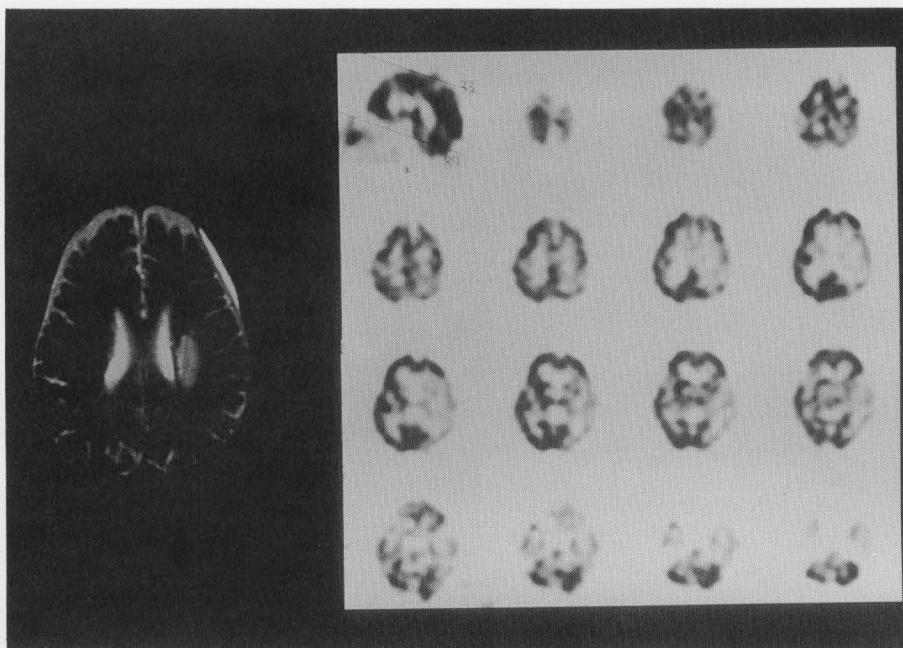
(left) T2-weighted MRI image. High intensity area which indicates infarction was observed in left white matter. (right) I-123 IMP SPECT images before surgery. Hypoperfused area in left middle cerebral artery (MCA) territory and crossed cerebellar diaschisis (CCD) were observed.
